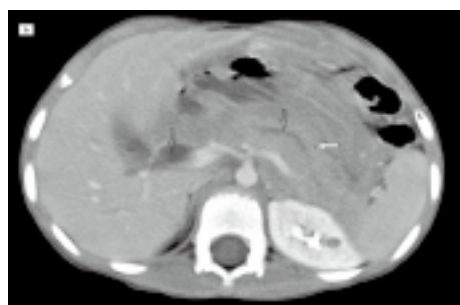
Post-contrast axial abdominal CT image shows diffusely enlarged pancreas (white arrow), dilatation of biliary and pancreatic duct (black arrows).
